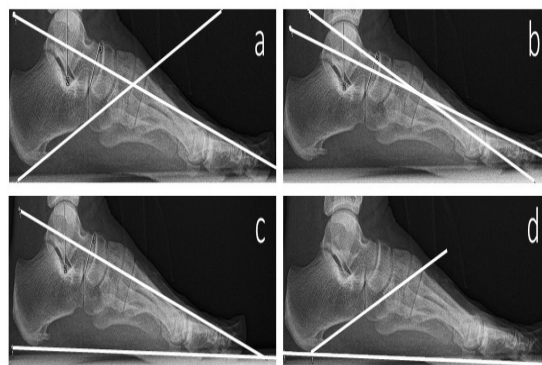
The Angles Measured on a Lateral Roentgenogram.
